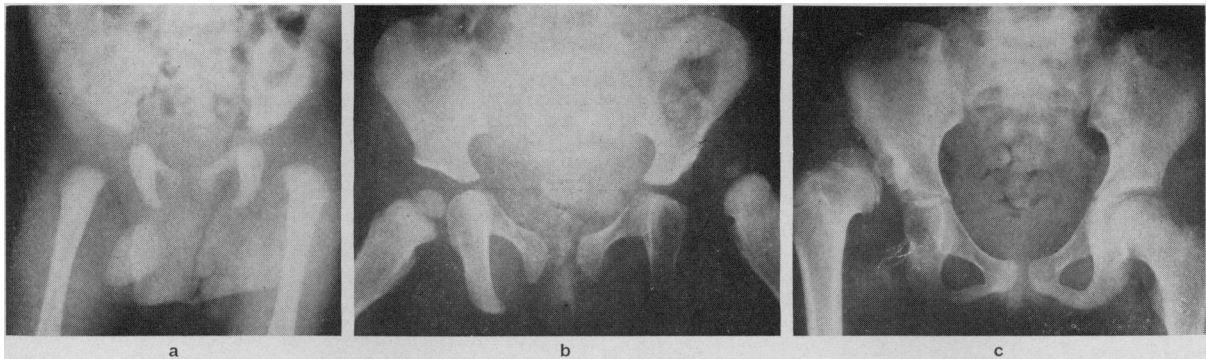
Radiographic dysplasia of the acetabulum. (a) A newborn infant; the left hip is completely dislocated but there is no evidence of dysplasia of the acetabulum. (b) A 15-month-old child with an untreated dislocation of the left hip; the dysplasia of the left acetabulum and femoral head is quite marked. (c) A 10-year-old girl with an untreated congenital dislocation of the right hip; the dysplasia of the acetabulum is extreme.
